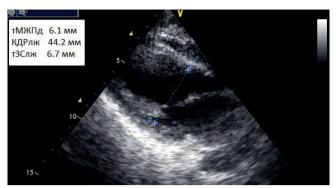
Echocardiography of a 21-year-old female patient at the time of admission. Parasternal long axis view.
